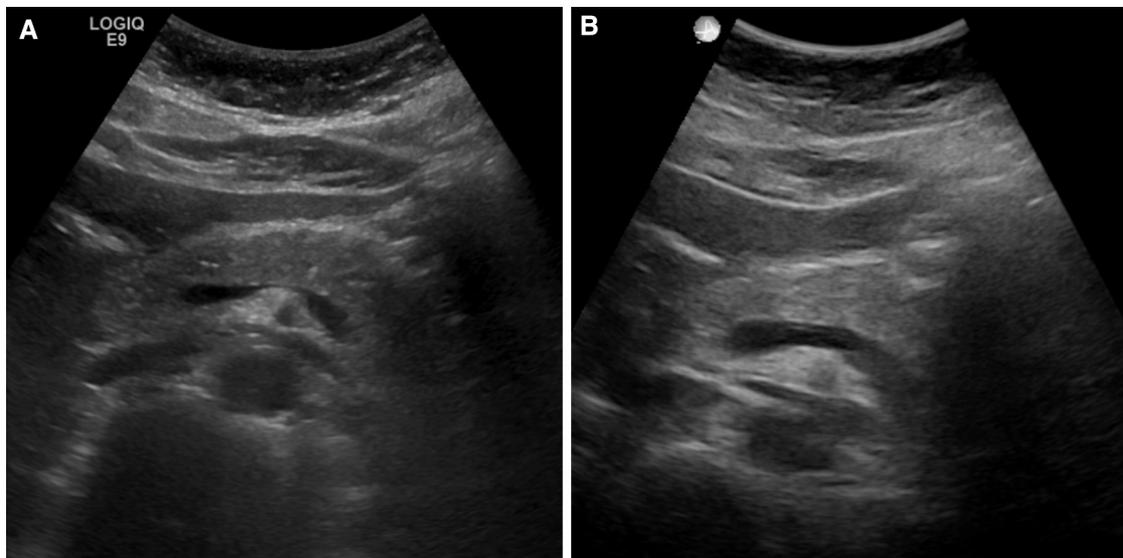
Transverse view of the pancreas in a 41-year-old woman obtained using the (A) LOGIQ E9 (conventional) ultrasound system and (B) SonixTablet/MELODY (telerobotic) system.
